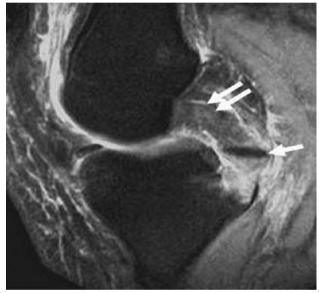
Sagittal STIR MRI image of the same patient in figure 3A, reveals contused PCL (double arrow) with avulsion of tibial bone fragment (single arrow).
